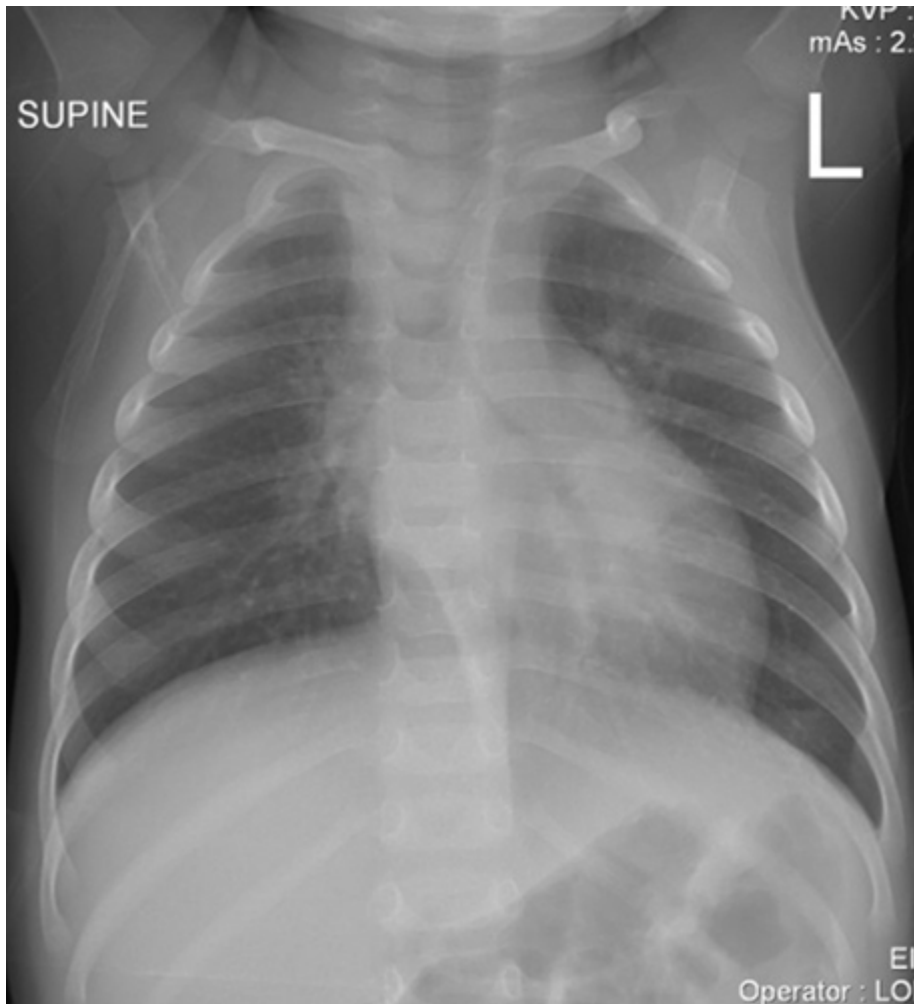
AP chest X-ray. Significant hyperinflation was visible bilaterally but very little parenchymal disease. There is a large airway obstruction with displacement of the trachea to the left, narrowing of the BV as well as the LMB. The right paratracheal, and right and left hilum lymph nodes (LNs) are present as well as significant subcarinal LNs. [↩](#)
